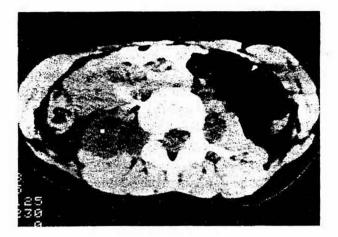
CT scan of the pelvis: at the level of the foramina intervertebralia L2-3 bilaterally and L3/L4 on the right the tumor extended in a lateral direction into the paretebral space.
